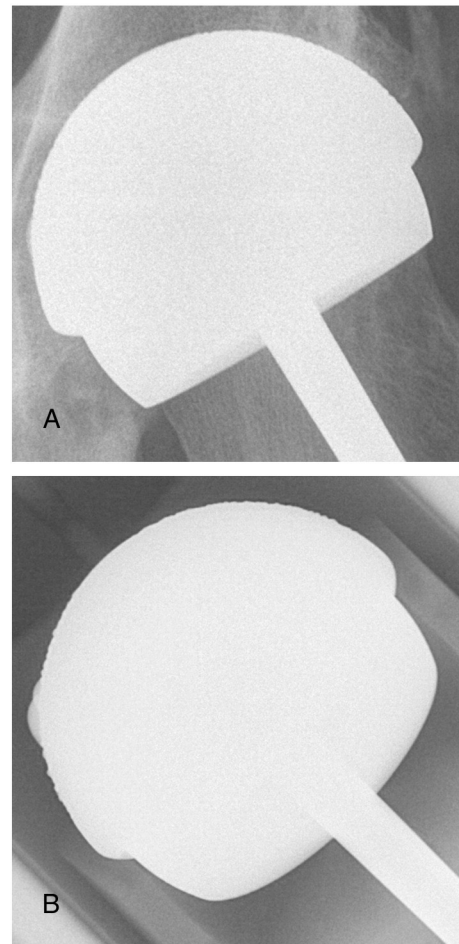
(A) A typical clinical radiographic image of a resurfacing hip prosthesis. (B) A radiographic image of a resurfacing hip prosthesis in the measurement jig.
